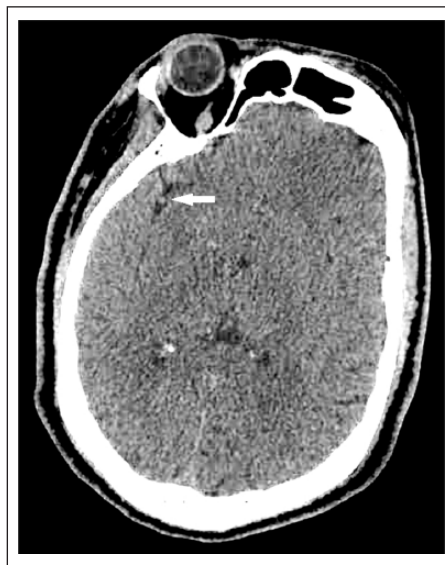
Non-contrast head CT, axial plane, 0.67 mm thickness, showing hyperdense MCA “dot” sign in the right Sylvian fissure.
